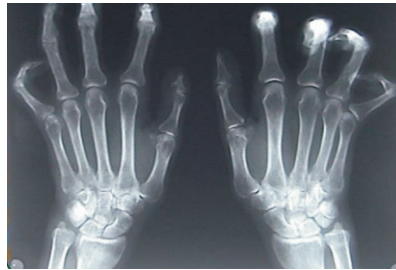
Hand and wrist radiograph showing calcinosis of the joints
